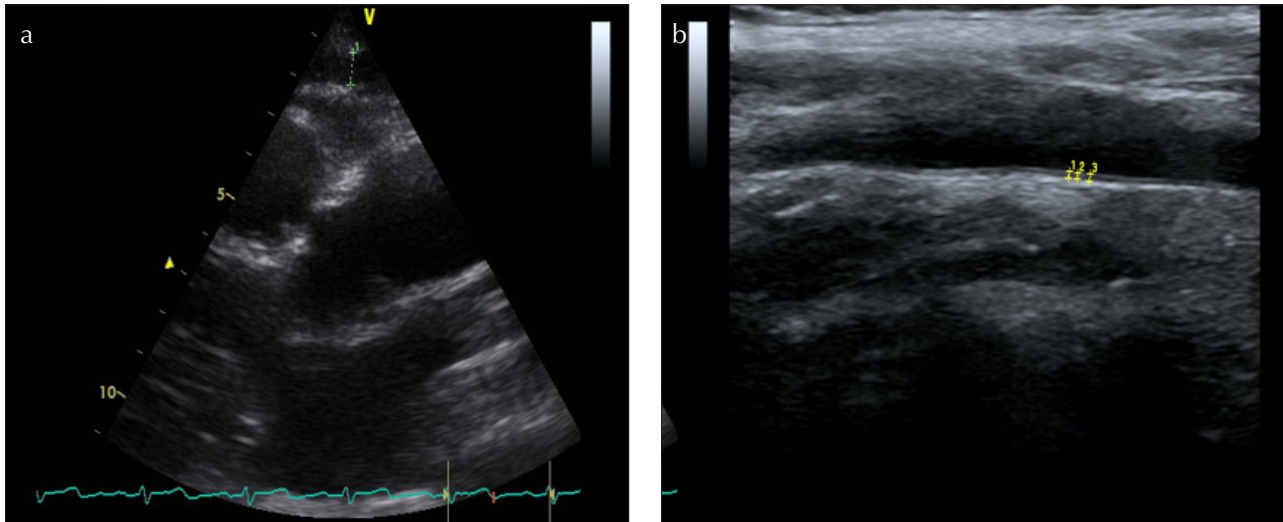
a, b. (a) Measurements of epicardial fat thickness on the free wall of the right ventricle from the parasternal long-axis views, (b) Measurement of carotid intima media thickness at the far wall of common carotid arteries
